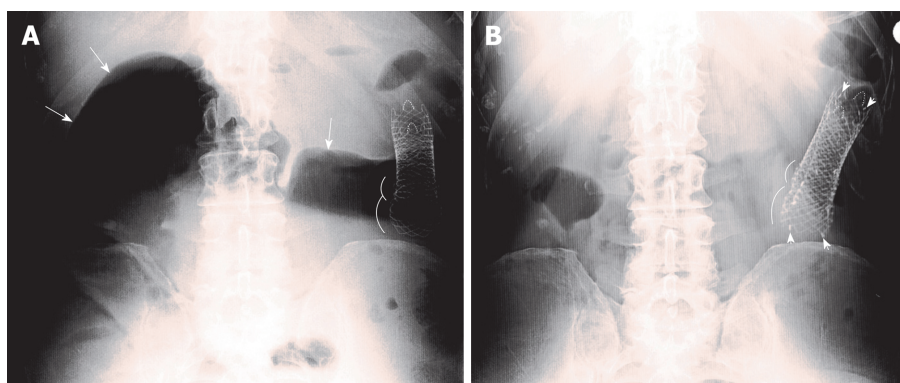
Abdominal X-ray before and after the positioning of the third stent. A: Large bowel massive distention (long arrows) without apparent stent migration; curves highlight the profiles of the proximal edges of the first and second previously placed stents; B: The third stent placed within the two previously placed stents (short arrows indicating some of the radiopaque markers), with detention of proximal loops.
